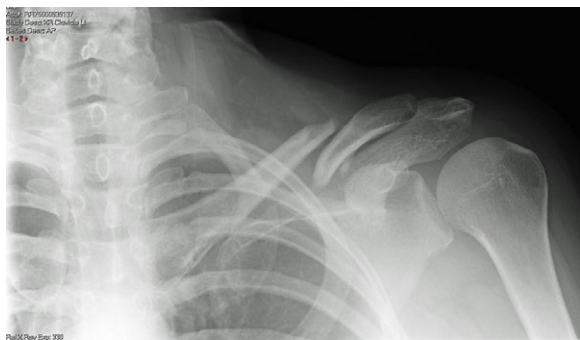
Lateral radiograph clavicle
